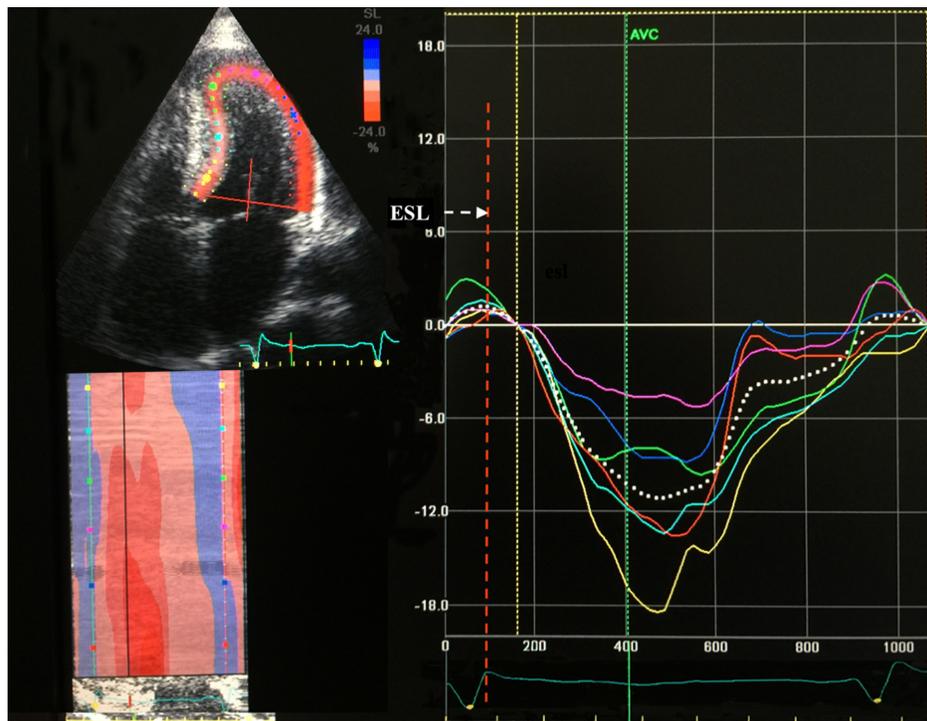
Echocardiographic image of early systolic lengthening measurement. AVC, atrioventricular canal; ESL, early systolic lengthening.
